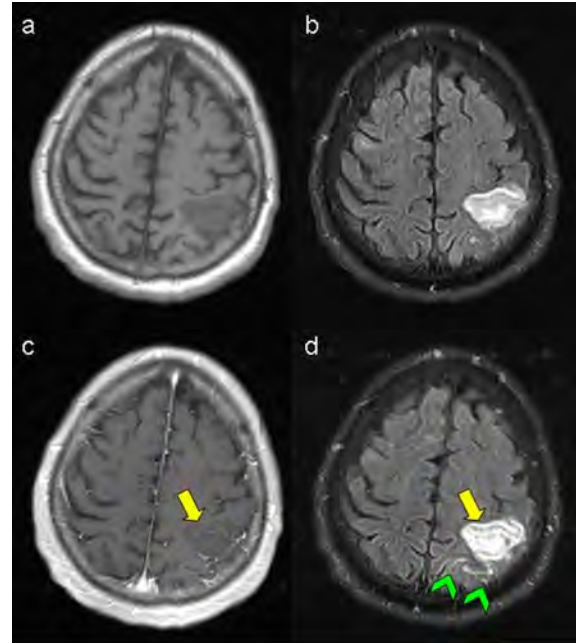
MRI of a 75 year old man with left MCA ischemia (a: T1, b: FLAIR, both without contrast agent) due to cardiac embolus. While there is evidence of some mild parenchymal BBB dysfunction on contrast-enhanced T1 (c, yellow arrow), this is more prominent on post-contrast FLAIR (d) that reveals additional sulcal hyperintensity and leakage of contrast agent to subarachnoid space adjacent to the acute ischemia (green arrowheads).
